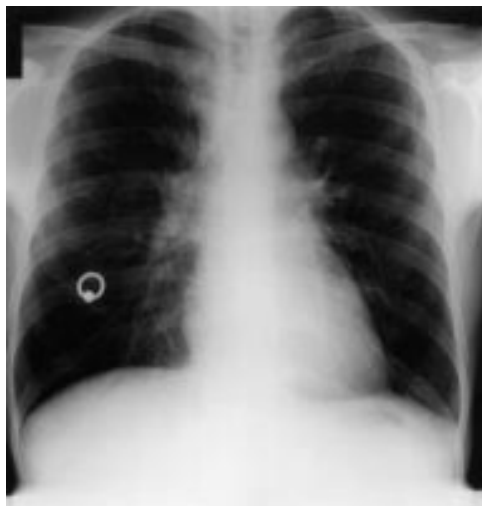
Chest radiograph on admission showing bilateral hilar and right paratracheal lymphadenopathy with diffuse reticular infiltrates and mild focal infiltrates at the left costophrenic angle and within the right mid-zone
